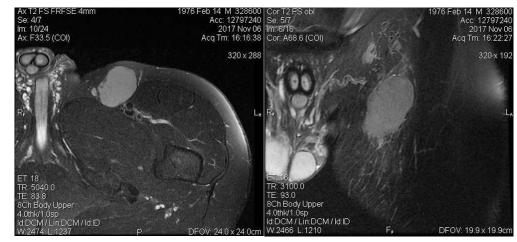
MRI showing the enlarged lymph node in left inguinal region
